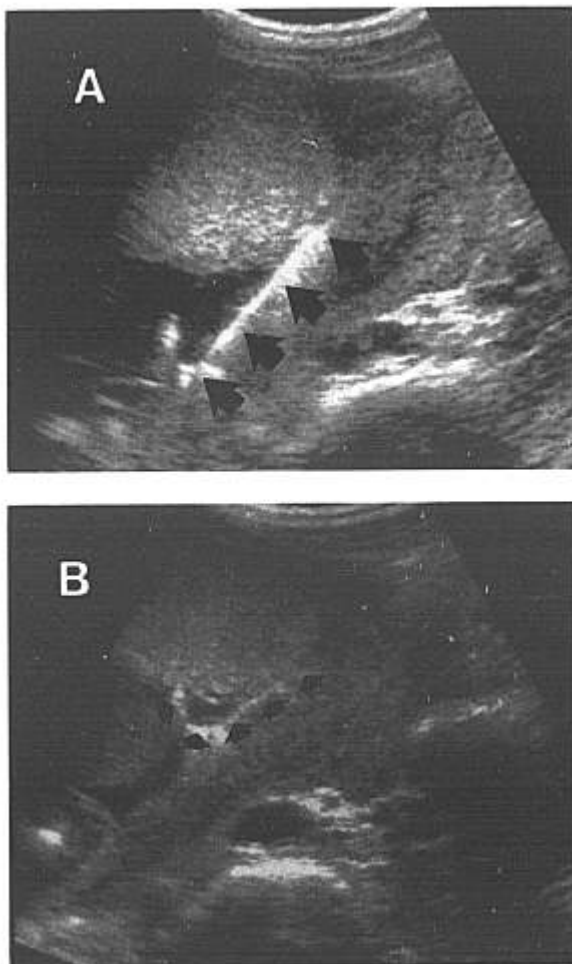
The Cordostat is visualized in the amniotic cavity under high-resolution ultrasound. A) The Cordostat (arrows), in the flexed mode, has been manipulated to grasp the umbilical cord (seen within the hook). B) The Cordostat has been retracted to stabilize the cord anteriorly.
